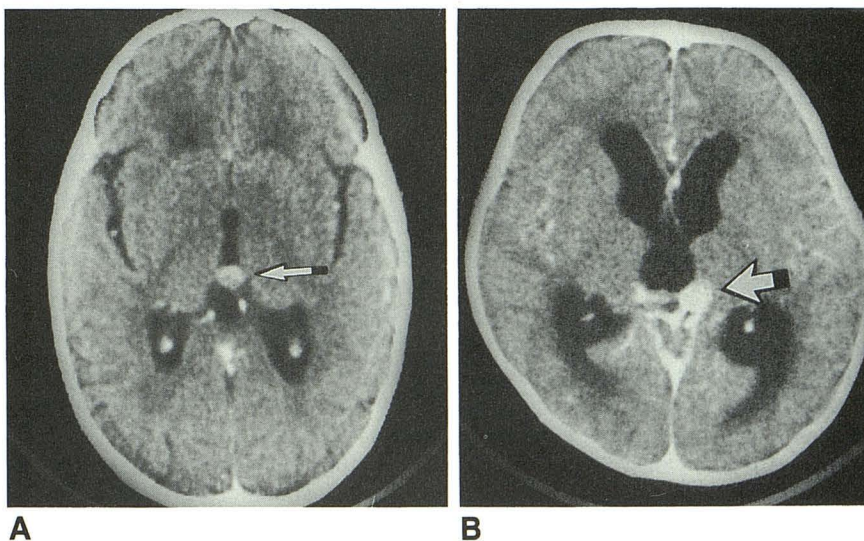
A and B, Postcontrast CT scans show nodular lesions in third ventricle (arrows).
